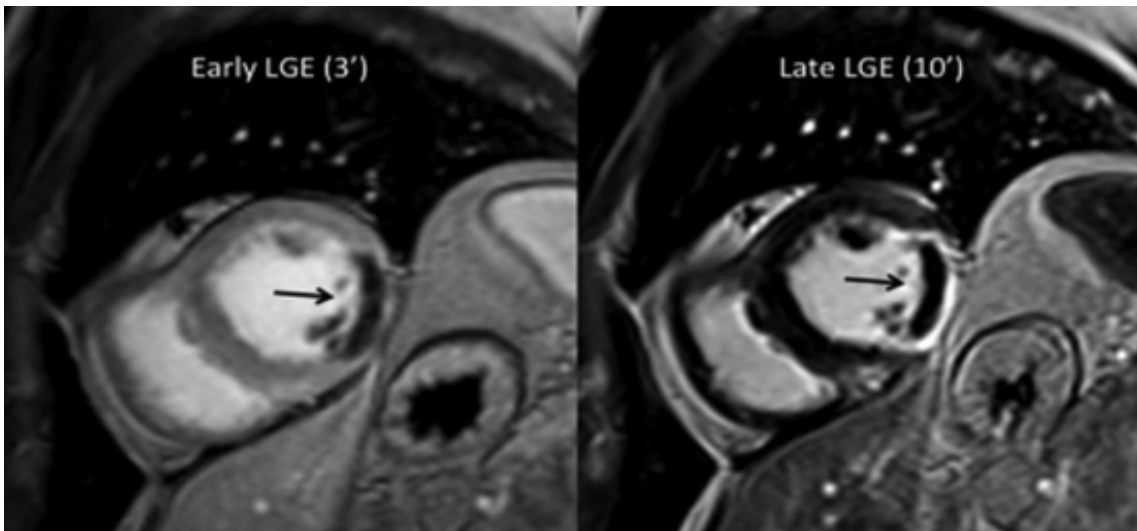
Short-axis view of early and late cardiac LGE-MRI in a subject with AMI. The MI occurs hyperintense on the late LGE image, with a subendocardial region (black arrow) corresponding to MVO. On the early LGE sequence, the MYO is still saturated with gadolinium, although the MVO already occurs hypointense (black arrow) [56].
